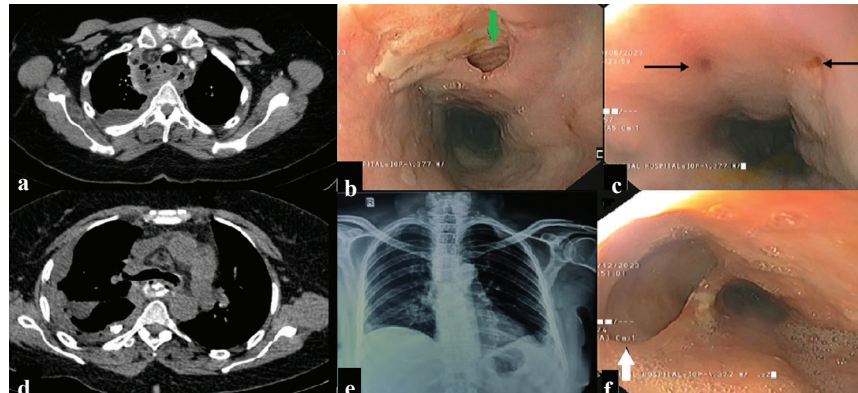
(a) Contrast-enhanced computed tomography (CT) scan of the thorax showing mediastinal air collection with right pleural effusion; (b) upper gastrointestinal endoscopy showing one large fistula with ulcer (green arrow) (c) two small fistulous opening in the upper third of the oesophagus (black arrows); (d) CT thorax with oral contrast showing long segment intramural dissection of oesophagus with leakage of contrast in the mediastinal space and pleural space; (e) normal chest X-ray at 2 months of antitubercular treatment; (f) endoscopy at 6 months showing healed ulcer with formation of diverticulum (white arrow)
